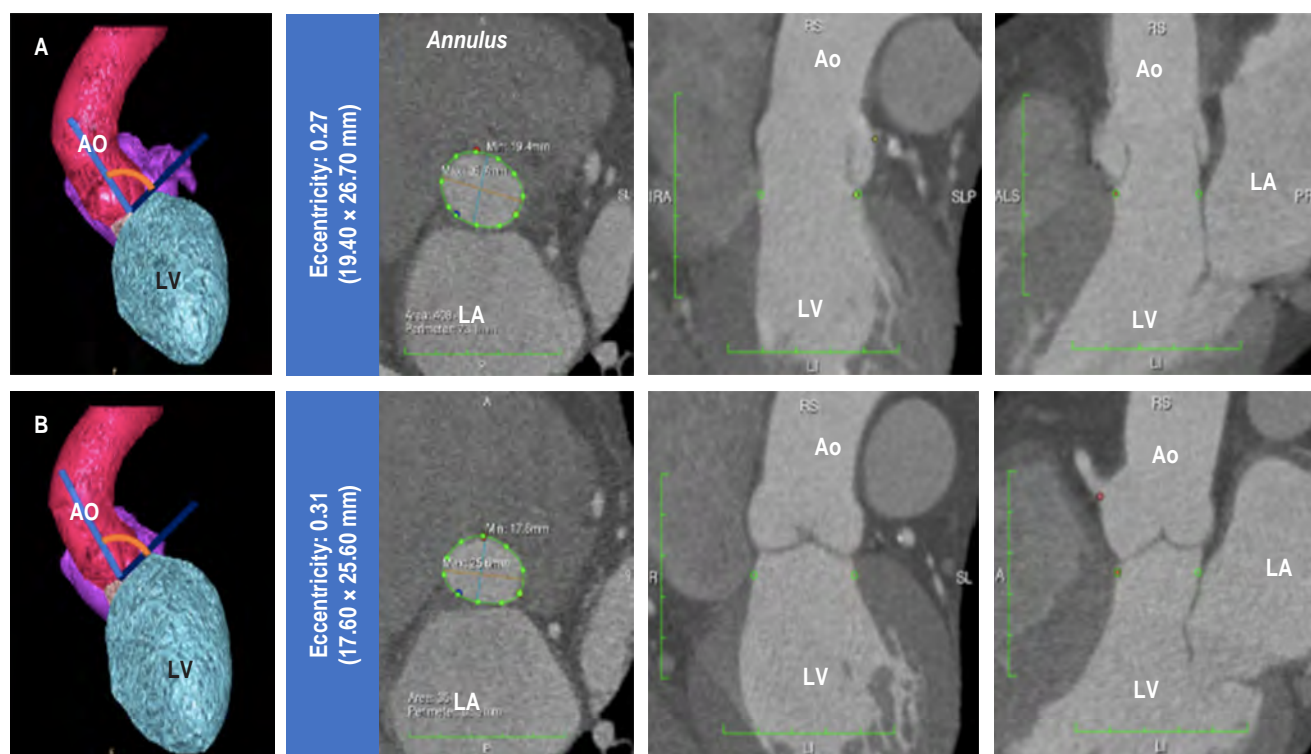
Cardiac computed tomography (CCT) analysis of the functional assessment of features of the aortic root during systole (A) and diastole (B). Left upper and bottom: aortic angulation, middle-upper, and bottom: aortic annulus dimensions, eccentricity, and area; right upper and bottom: coronal and sagittal views of the AR. Ao = aorta; LV = left ventricle; LA = left atrium.
